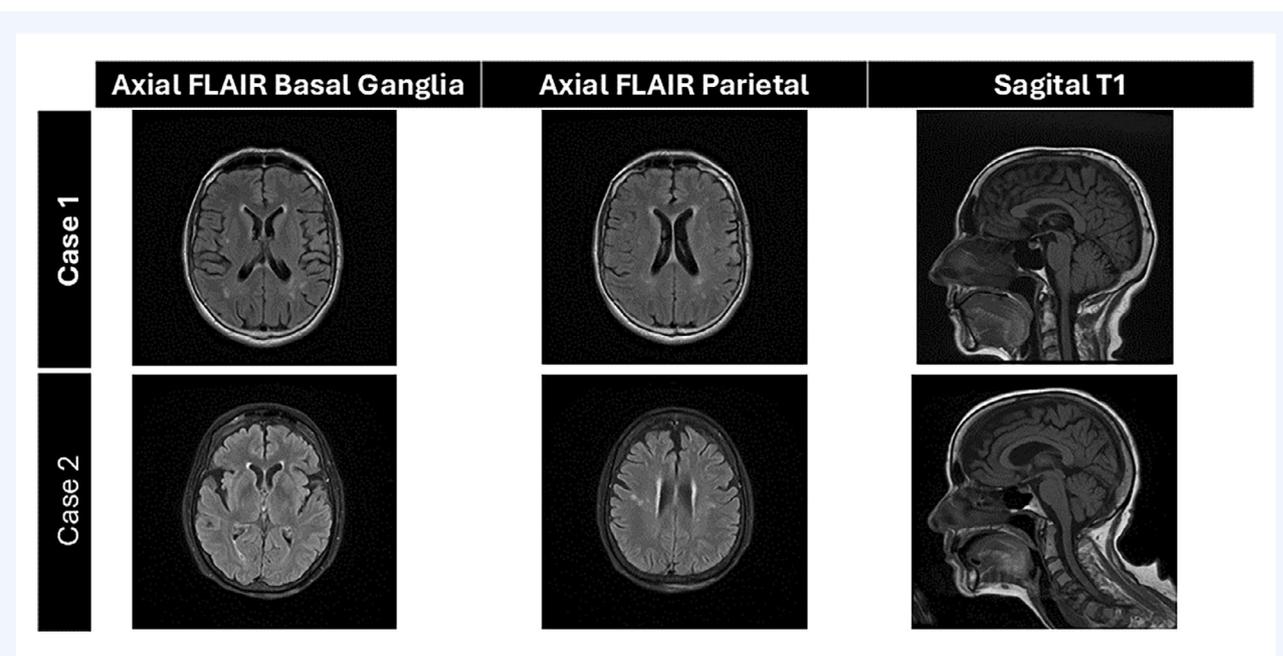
1.5-T Magnetic Resonance Imaging (MRI) axial fluid-attenuated inversion recovery and sagittal T1 displaying in both cases nonspecific symmetric generalized atrophy and white matter hyperintensities.
